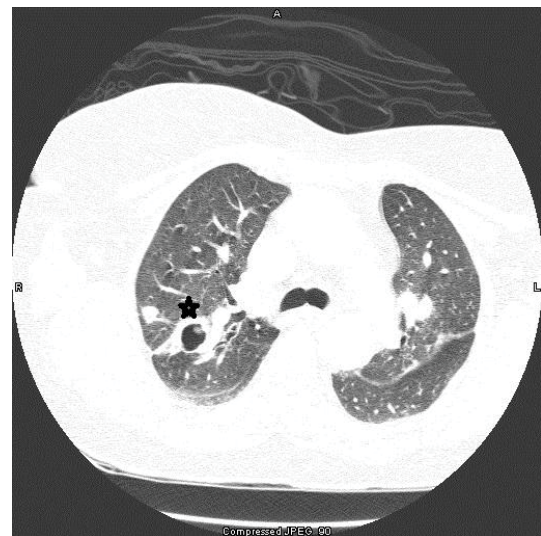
Computed tomography demonstrating right upper lobe cystic cavity (starred) and adjacent pulmonary nodule.
